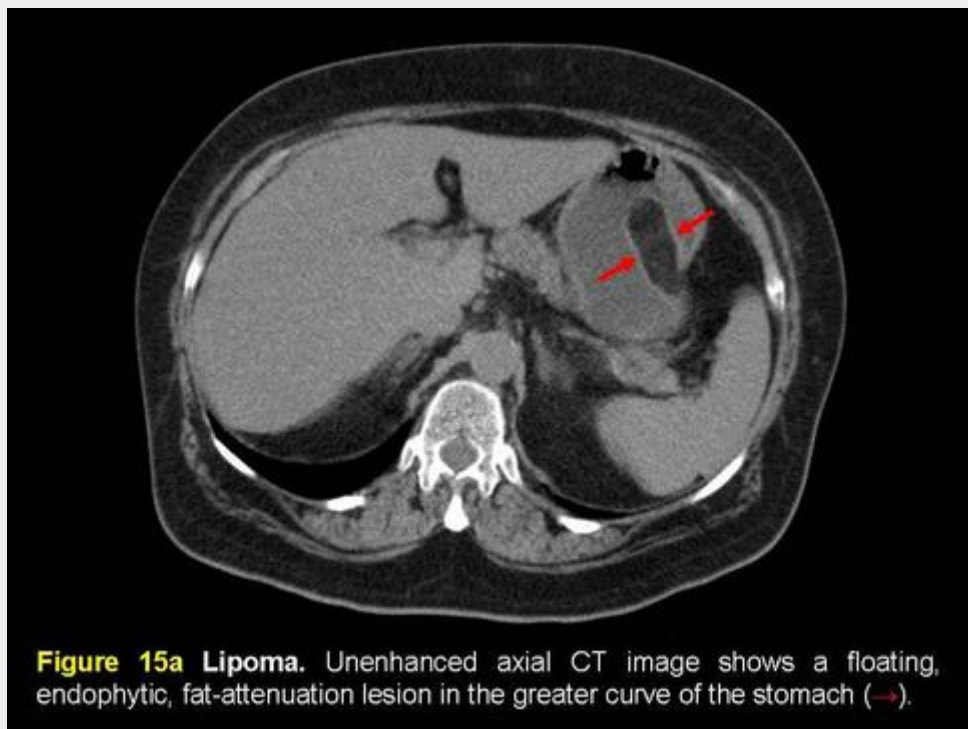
Lipoma. Unenhanced axial CT image shows a floating, endophytic, fat-attenuation lesion in the greater curve of the stomach (→).
